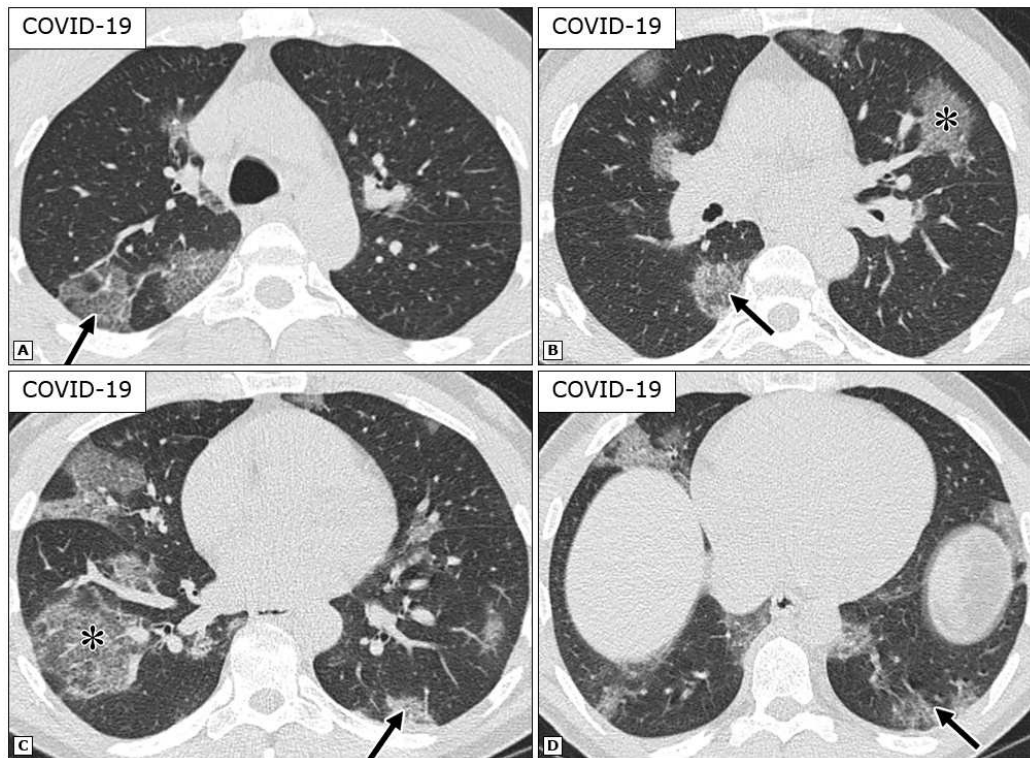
Chest CT findings related to COVID-19⁵⁶
